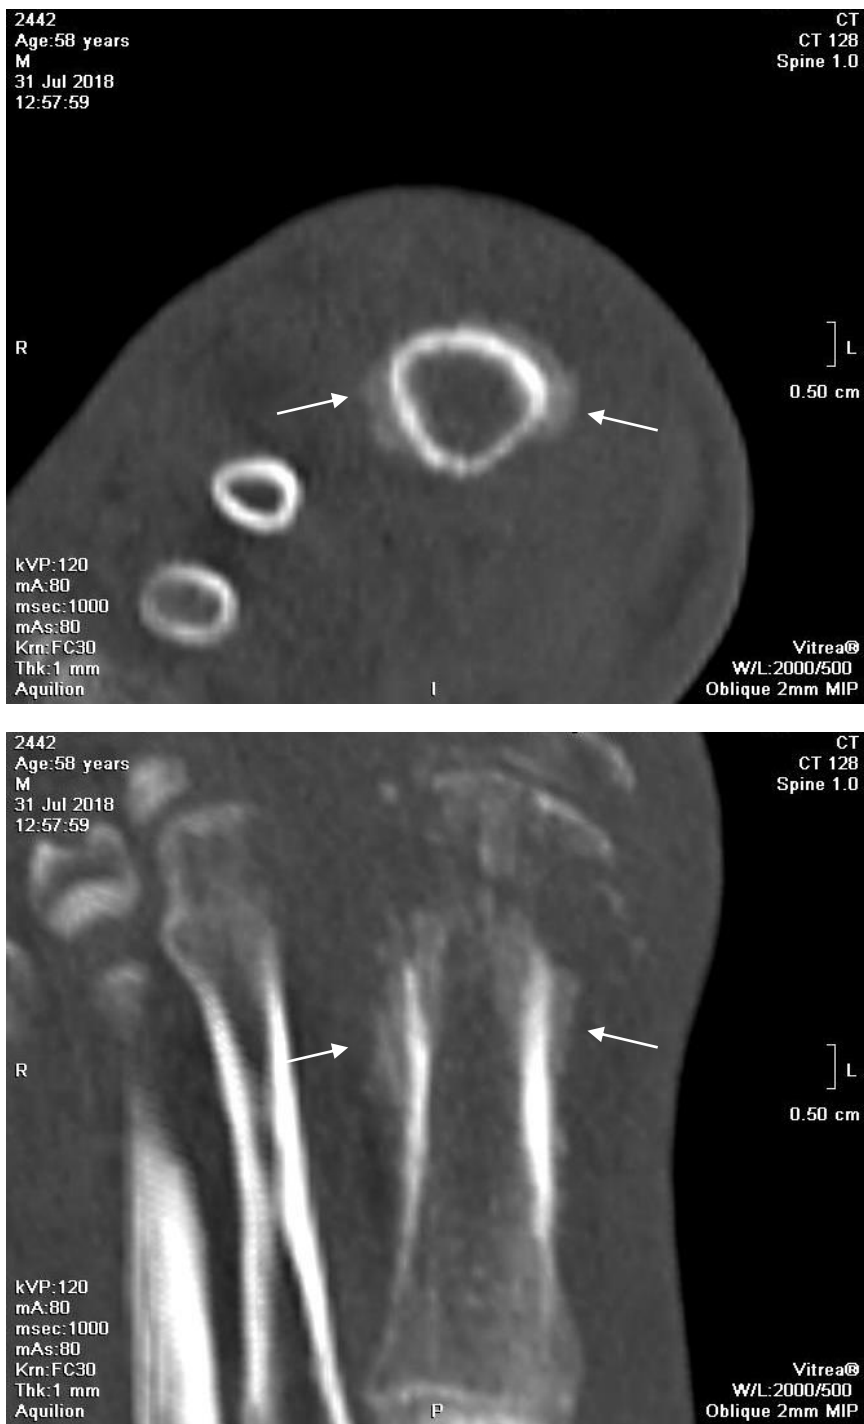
Right leg CT images at presentation show periosteal reaction involving first metatarsal bone (the same patient as in the Figure 7)
